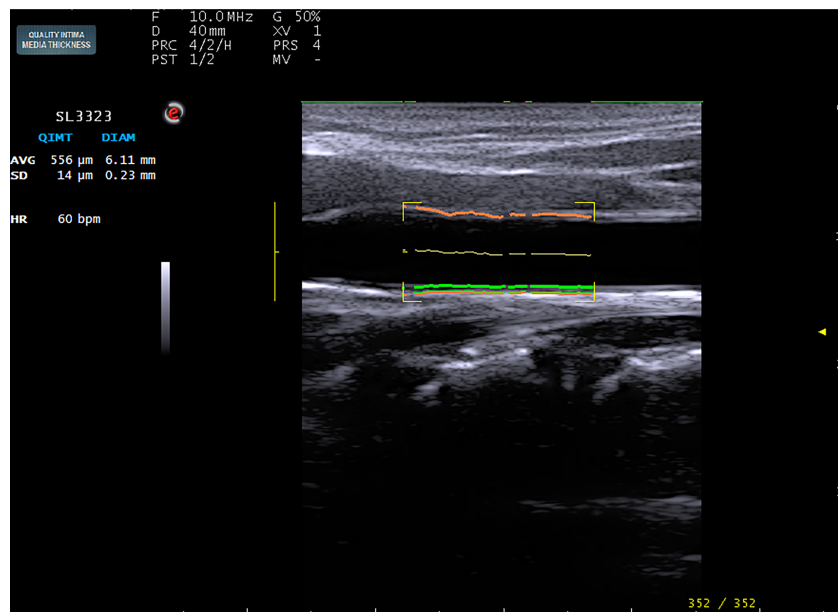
CAROTID ULTRASOUND IMAGE.
